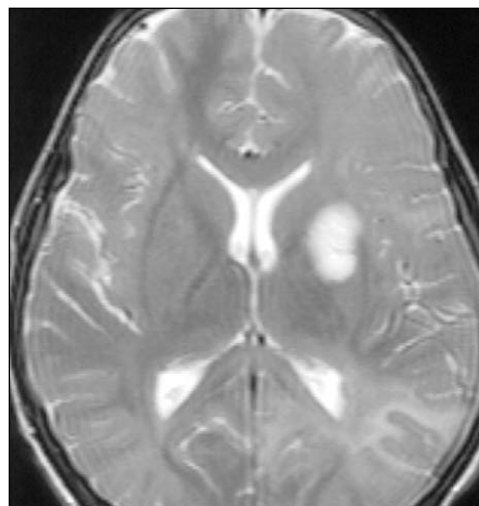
Axial T2 weighted brain MRI showing significant white and gray matter involvement with bilateral hyperintense signals maximally involving the left hemisphere
